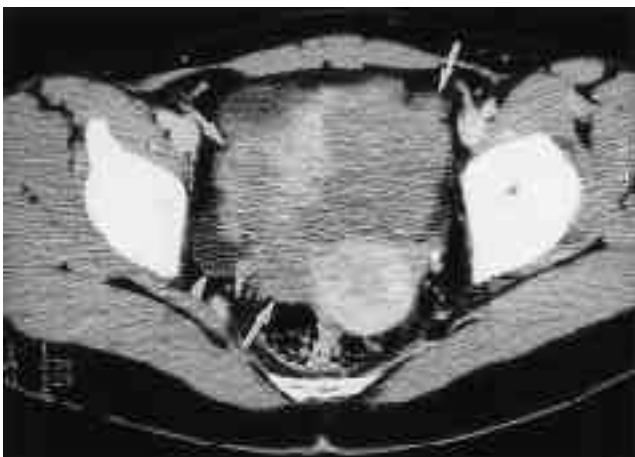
A 19-year old woman with right ovarian dysgerminoma. Contrast enhanced CT scan shows well defined lobulating contour mass(arrows) in the pelvic cavity which abuts on the anterior surface of the uterus and demonstrates less enhancement than that of myometrium. Small amount of ascites is noted in the right ovarian fossa(arrowhead), both ovaries are not visualized.
